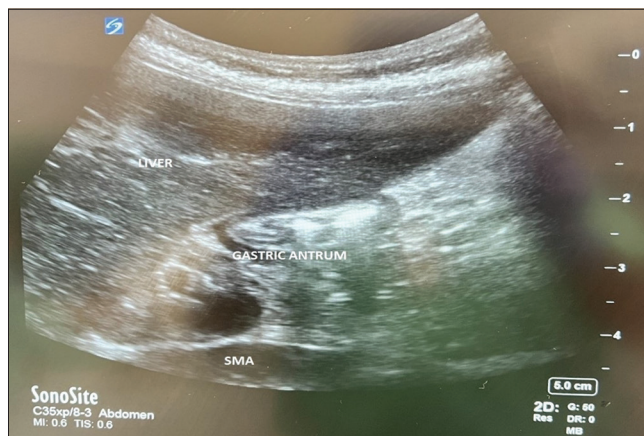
Sonographic image of the gastric antrum of an empty stomach. The antrum appears flat and collapsed, with no visible content (Grade 0); SMA, superior mesenteric artery
